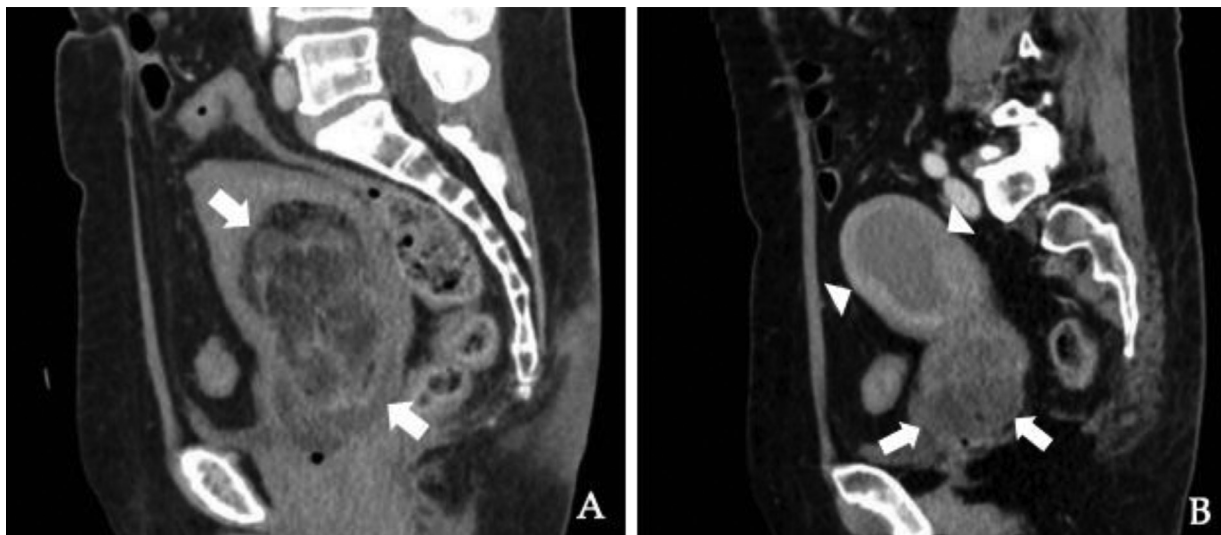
Sagittal contrast-enhanced CT Multiplanar (MPR) reconstruction: (A) well depicted extension of pleomorphic LPS of the uterine corpus (black arrows). (B) Lipoleiomyosarcoma arising from the cervix (white arrows) with distension of above endometrial cavity (white arrowheads).
